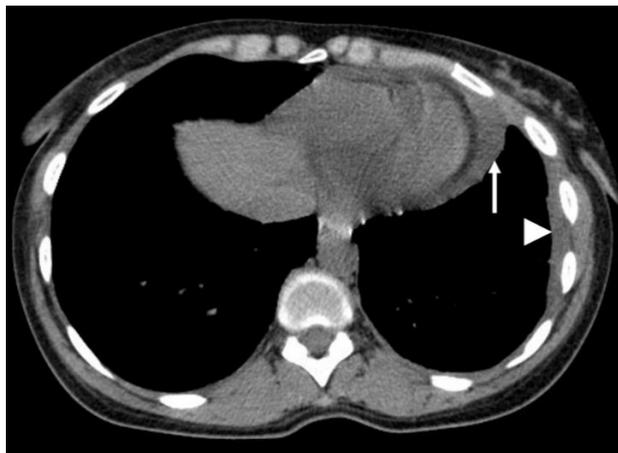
Axial unenhanced chest CT (mediastinum window). There is a thin layer of pericardial and left lateral pleural hypodense fluid (effusions)
